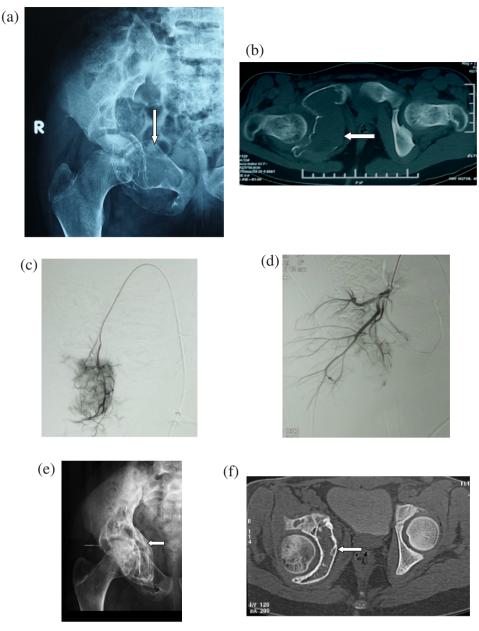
ABC at right acetabulum and right pubic bone underwent curative embolization. (a) Plain X-ray of right hip joint demonstrates the lesion (arrow). (b) Axial CT demonstrates expansile aggressive ABC (arrow). (c) Preembolization angiogram of Rt. internal iliac artery shows tumor blush with microcatheter is then advanced into tumor feeding artery. (d) Postembolization angiogram shows absent tumor blush. (e) Follow up after 6 months plain X-ray at AP view reveals tumor shrinkage with sclerotic margin. (f) Follow up after 2 years axial CT reveals persistent tumor shrinkage and evident sclerosis.
